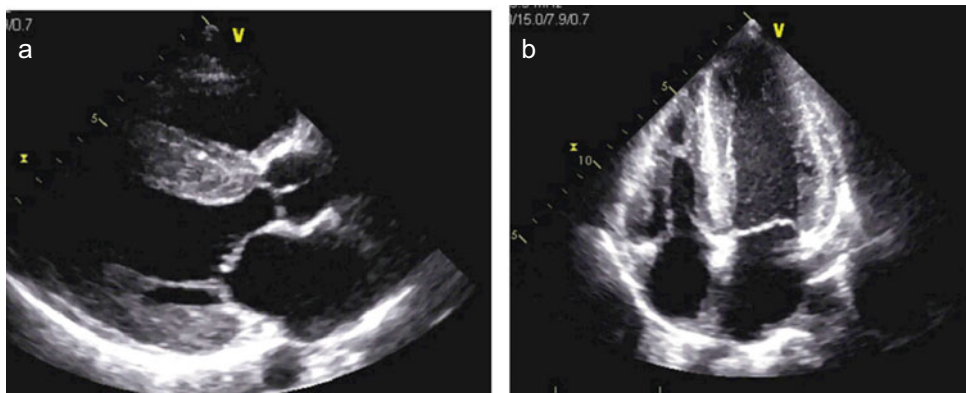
a Parasternal long-axis view. Interventricular septum thickness measured 1.8 cm. Calculated LV mass = 164 gm/m² consistent with concentric “left ventricular hypertrophy.” b Apical four-chamber view. Left atrium is dilated (LA volume = 38 ml/m²). Thickening of right ventricular wall
